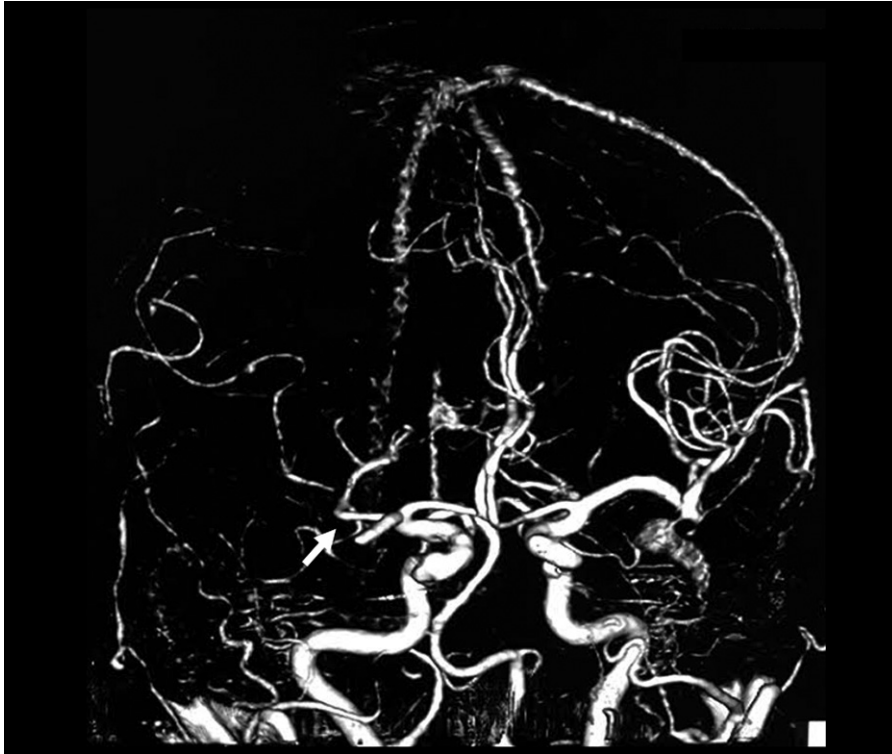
Frontal view on cerebral arterial 3D-CTA (volume rendering) on arrival. The right MCA (M1) was occluded (arrow). 3D-CTA: three-dimensional computed tomography angiography; MCA: middle cerebral artery
